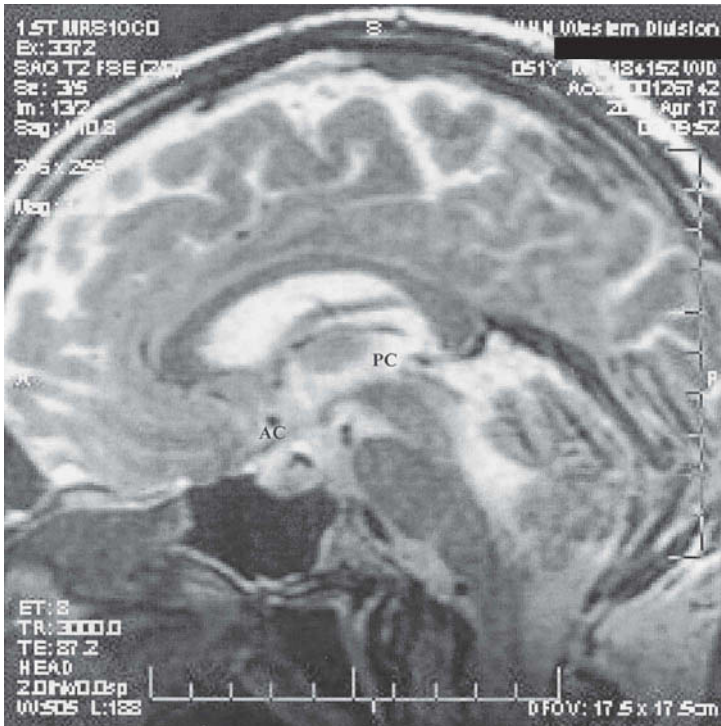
Mid-sagittal T2-weighted MRI section demonstrating the location of the anterior commissure (AC) and posterior commissure (PC). Note that PC lies dorsal to the tectal plate, while AC lies inferior to the anterior fornices.
